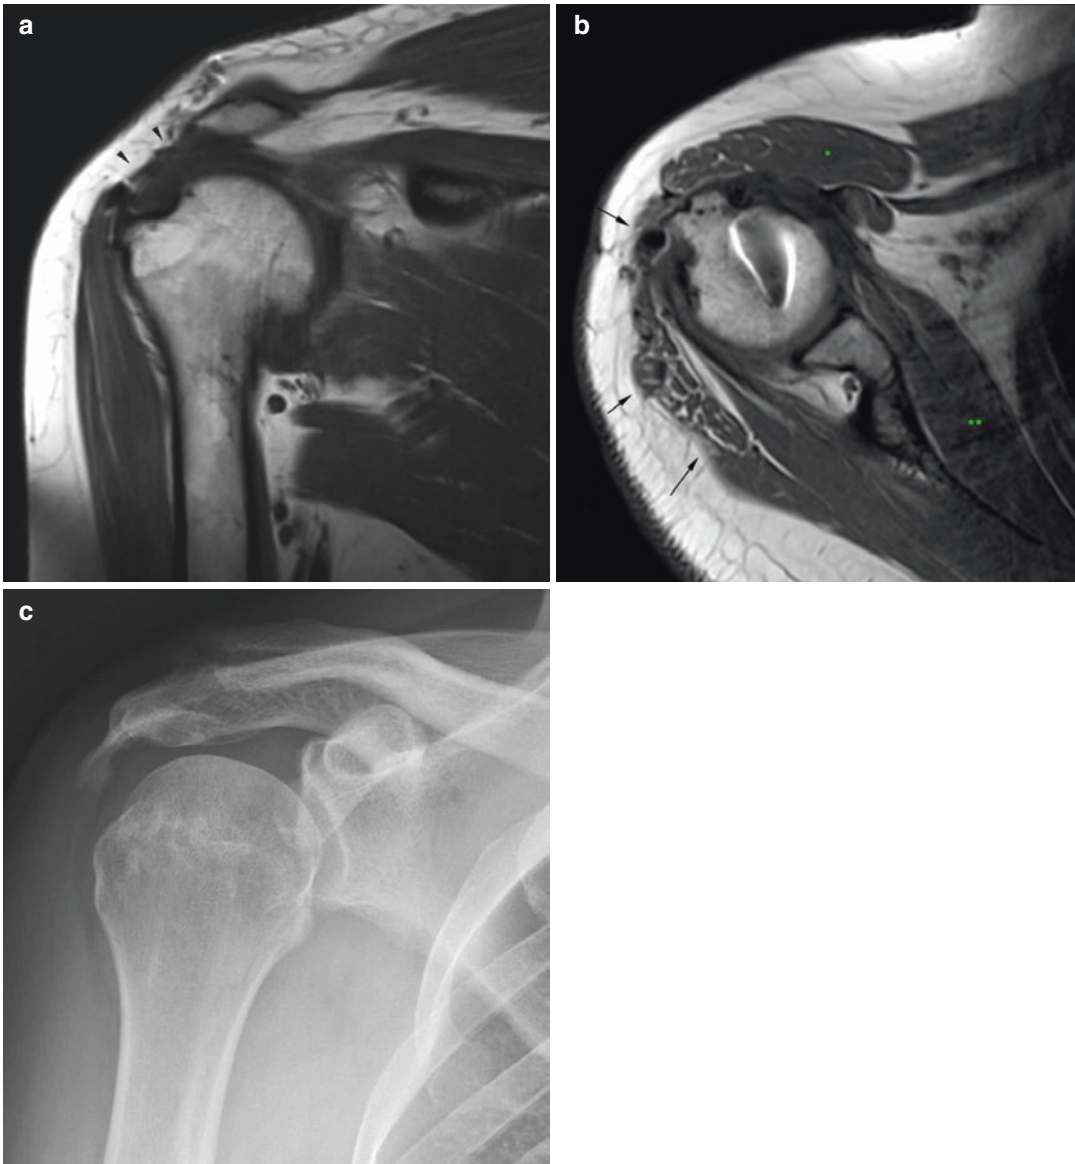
(a–c) Cuff repair follow-up. Chronic deltoid dehiscence. (a) Postoperative T1-weighted coronal MR image. (b) Postoperative T1-weighted axial MR image. There has been detachment of the deltoid muscle from the acromion (arrows) with atrophy and fatty degeneration of the acromial belly of the deltoid muscle (arrows). For
